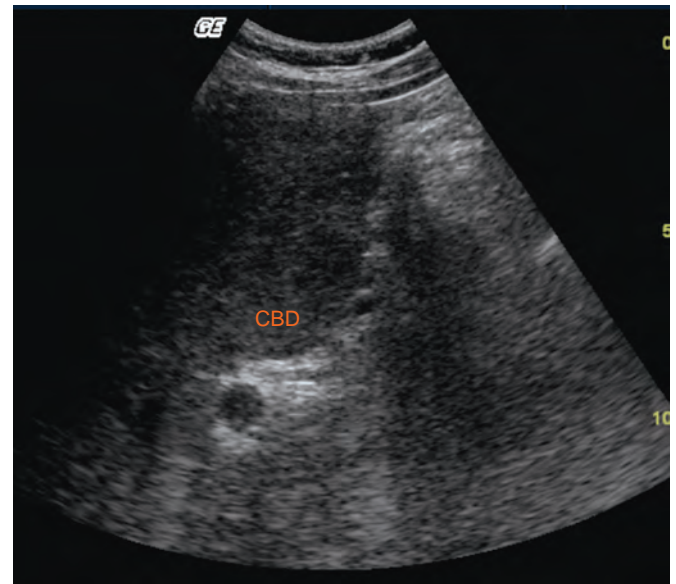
PSC: sonographic findings. Mural thickening of the common bile duct (CBD) is identified on this transverse sonogram.
